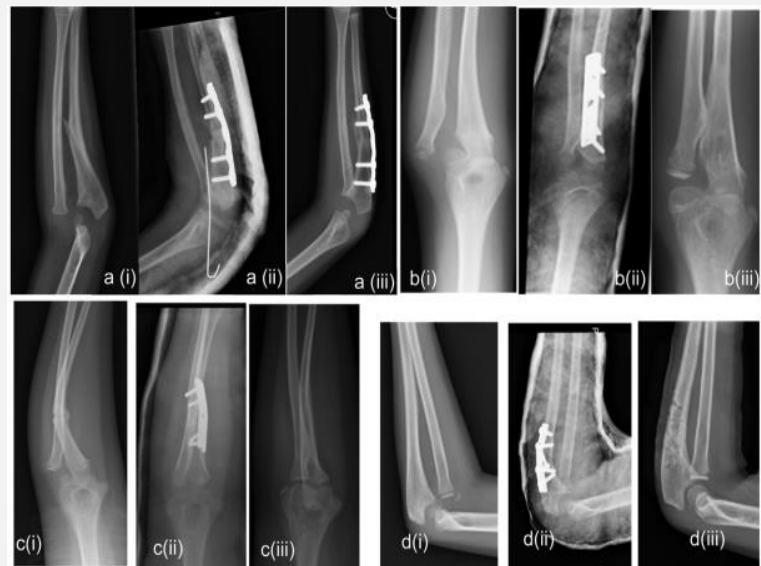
The plain radiological view of each patients, including patients No. 1 (a), No. 2 (b), No. 3 (c), and No. 4 (d). The radiograph at the time of presentation (i), the post-operative radiograph in POP (ii), and the radiograph at the most recent follow-up (iii). The radio-capitellar Kirschner wire is visible in radiograph a(ii), which is the first post-operative radiograph.
